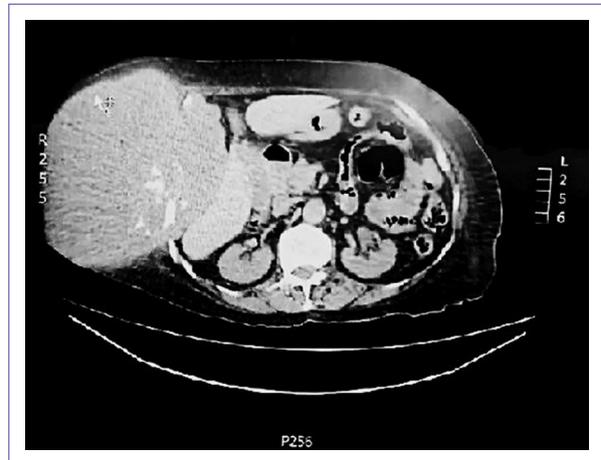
Simple axial computed tomography, axial section. Tumor dependent on the 9th right costal arch of 20 × 20 cm, displacing structures (liver and lung), with areas of calcification in its interior.
